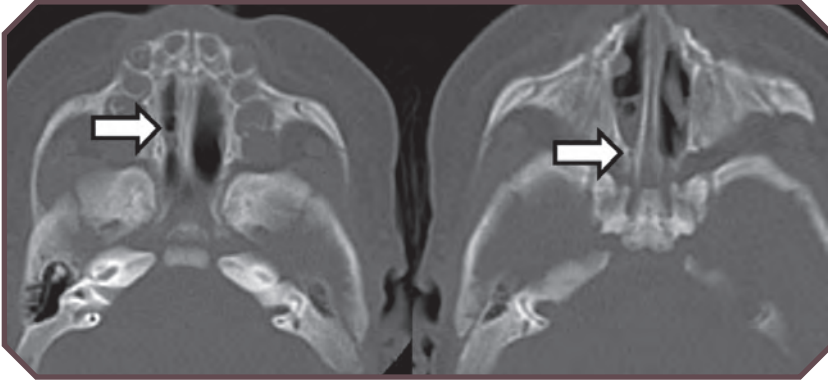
Choanal atresia in a 1-day-old female neonate with difficulty breathing. Axial computed tomographic bone window images show narrowing of the right nasal canal (arrows).
